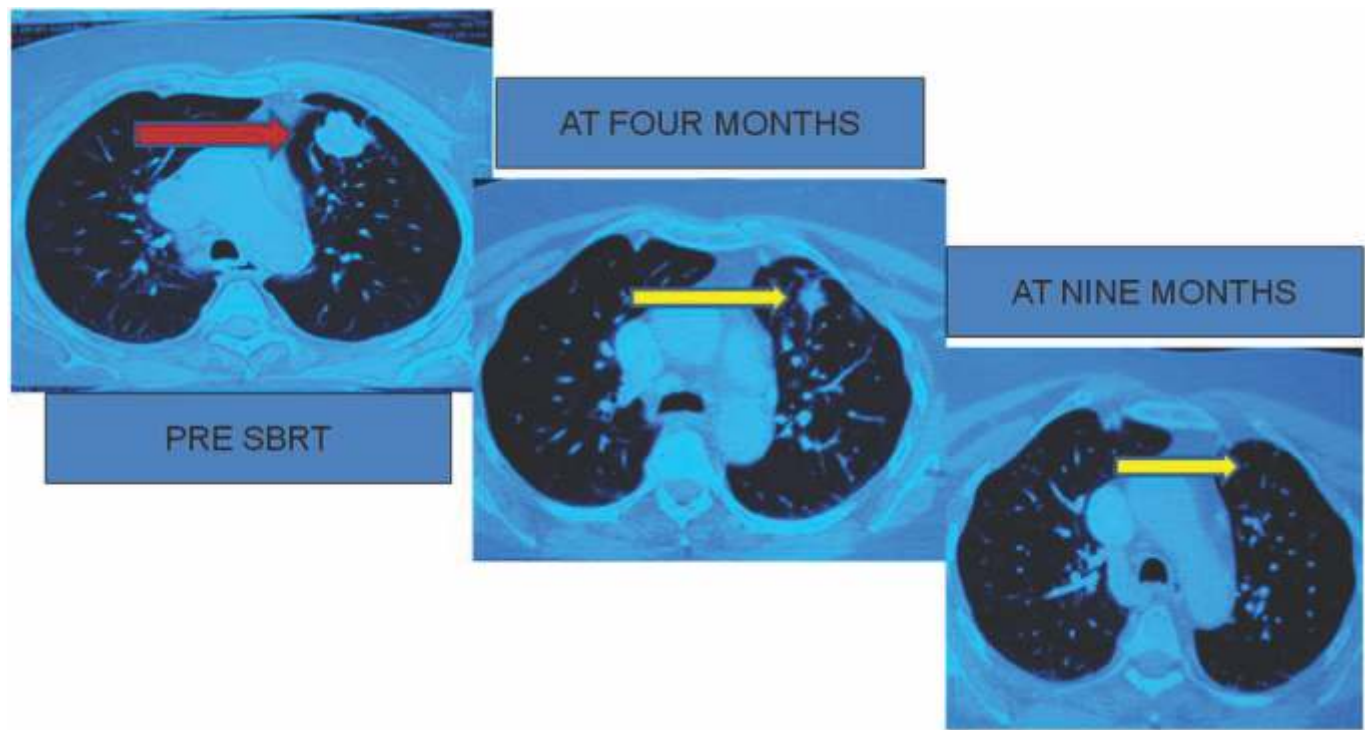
Pre and post SBRT follow-up CT scans. Last follow up 14.02.2015 (38 months) - in CR
